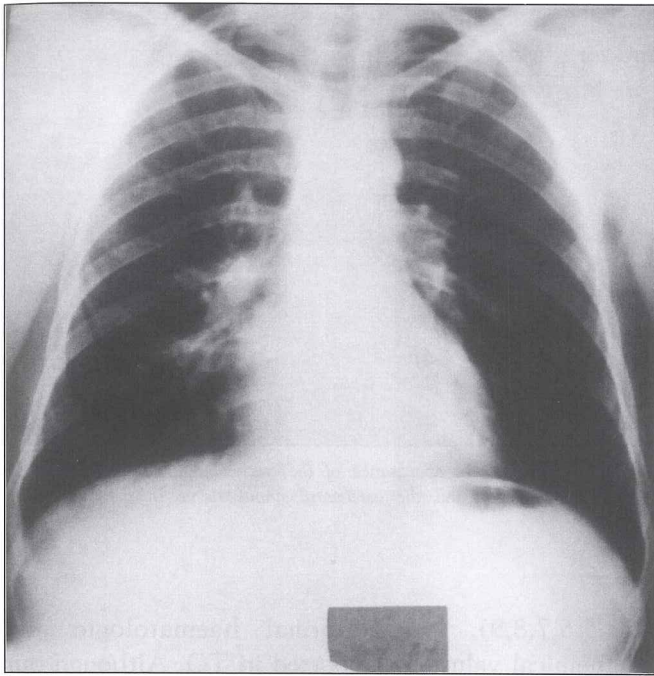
The posteroanterior chest X-ray of the patient.
